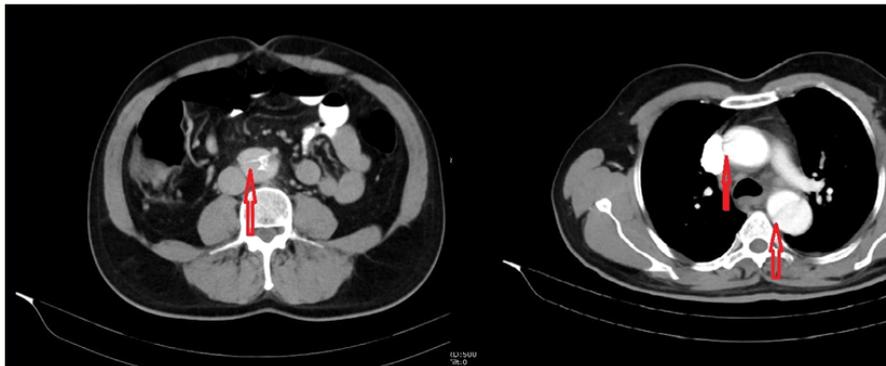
Computed tomography imaging revealing dissection involving the ascending and descending aorta (arrows).
